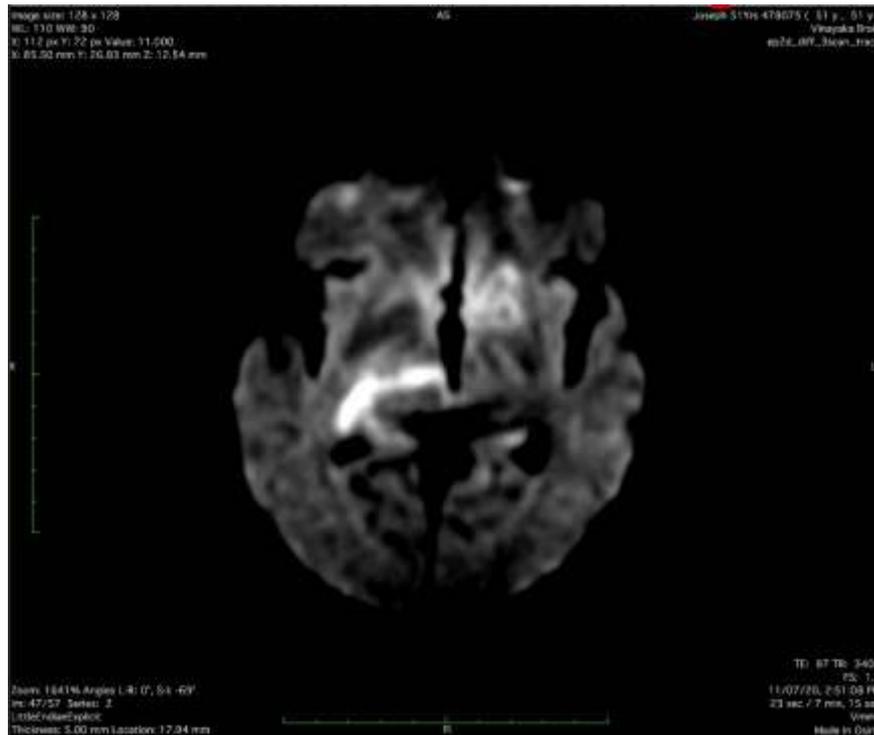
Axial T2/FLAIR images shows asymmetrical patchy areas of high signal intensity involving the right temporal region with multiple punctate high T2 signal lesions around the periventricular and subcortical white matter
